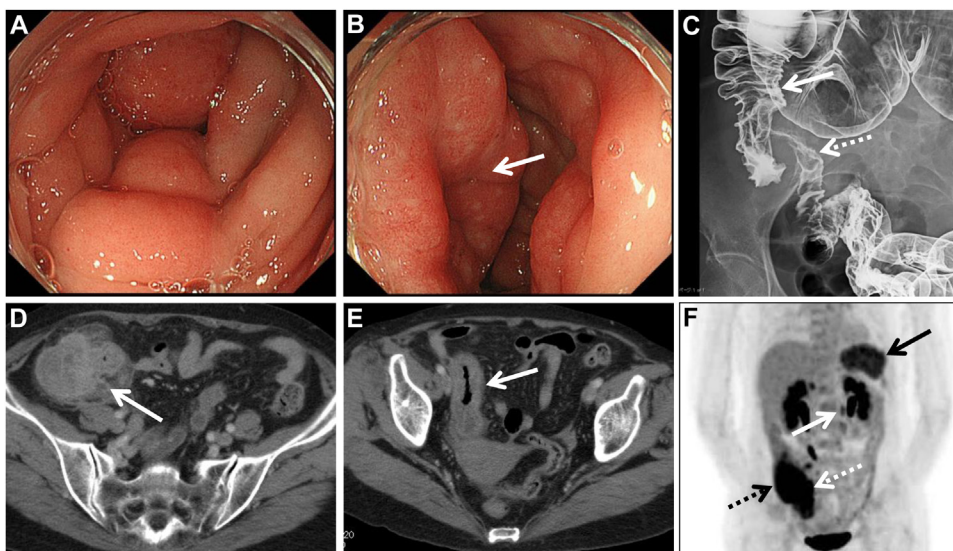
(A, B) Colonoscopy revealed moderate stenosis caused by edematous wall thickening of the lower ascending colon with reddening of the mucosa (A) and a swollen ileocecal valve (B; arrow). (C) A radiographic contrast enema indicated the presence of edematous asymmetrical stenosis, with erosion of the terminal ileum and lower ascending colon (arrow, ascending colon; dotted arrow, terminal ileum). (D, E) Abdominal CT scans indicated edematous wall thickening of the lower ascending colon (D; arrow) and terminal ileum (E; arrow). (F) FDG-PET revealed increased FDG uptake in the ascending colon (SUV max: 13.3; black dotted arrow), terminal ileum (SUV max: 6.9; white dotted arrow), spleen (SUV max: 5.9; black arrow) and paraaortic lymph node (SUV max: 5.3; white arrow).
